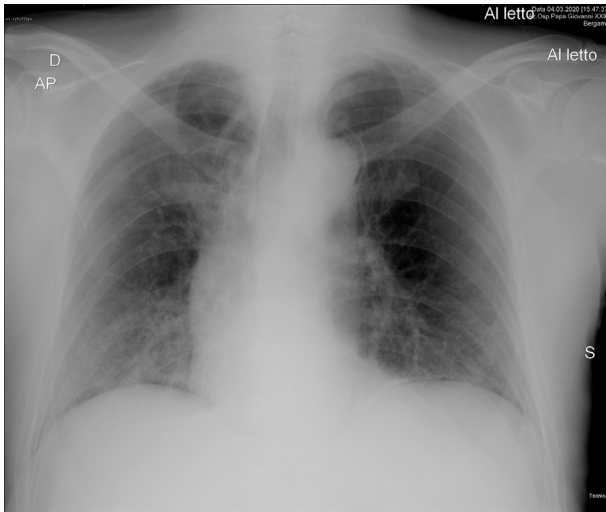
March 4 2020 Chest X-ray.
